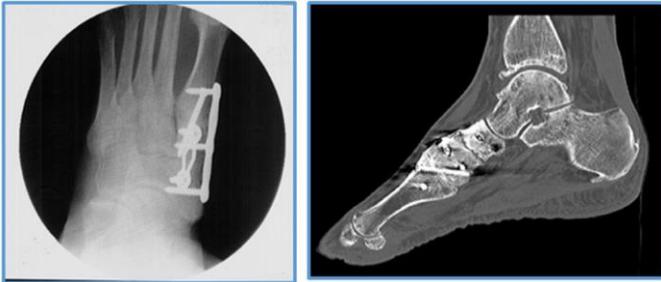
(A) Radiograph demonstrating intact hardware with the presence of a non-union of the naviculocuneiform joint; (B) CT scan confirming non-union of the naviculocuneiform joint
